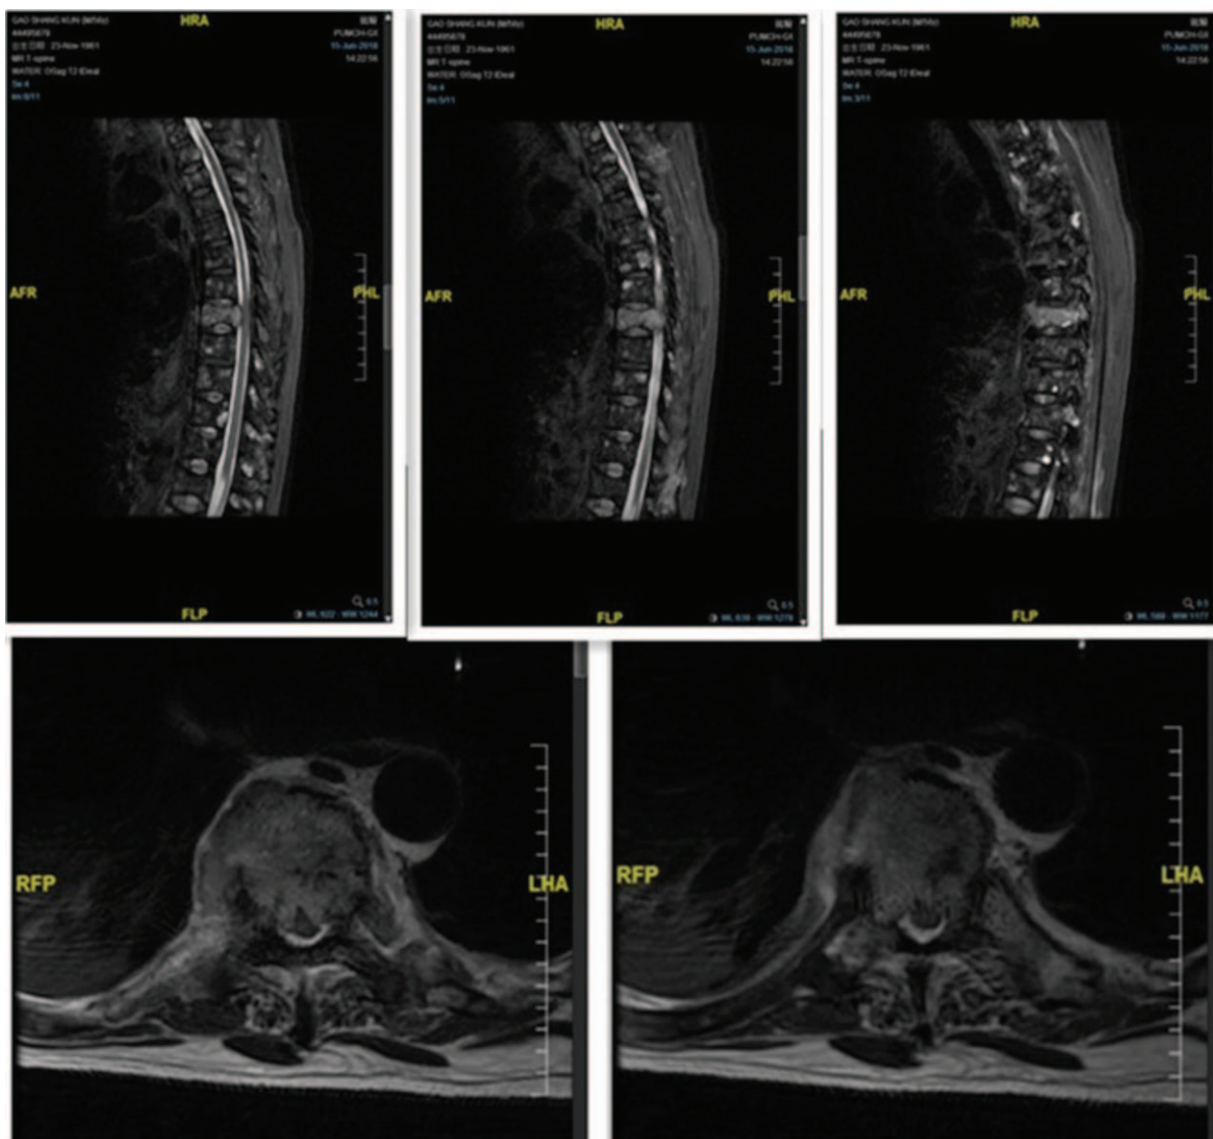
Thoracic MRI showed severe damage of T8 vertebrae and compression of the spinal cord.
